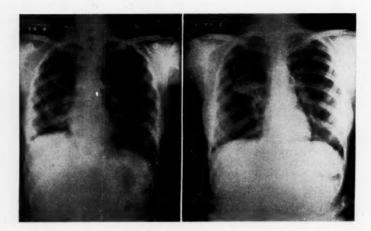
a, Roentgenogram made at two months' interval, showing the development of atelectasis of the right upper lobe. b, Although pneumothorax therapy was abandoned, the atelectatic lobe failed to re-expand.
